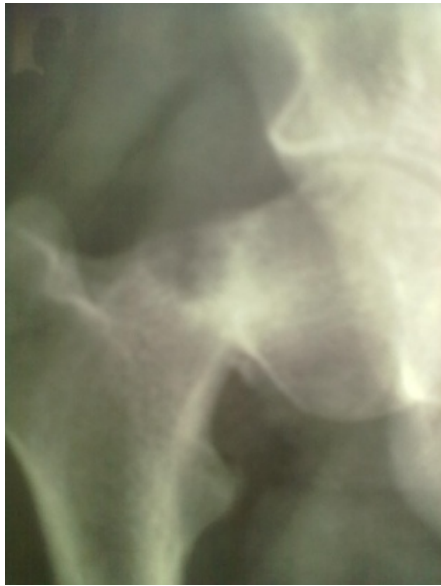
Case 1: Preoperative x-ray
